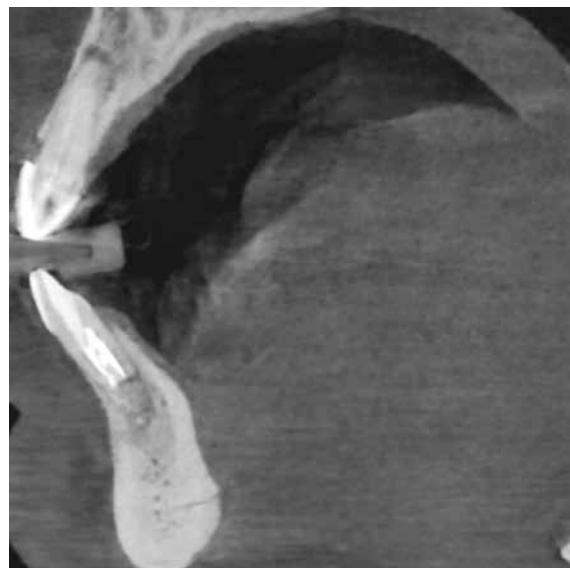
CBCT cross section at 6 months demonstrating replacement of the Bond Apatite® with new host bone maintaining the facial contour of the mandible that was affected by the lesion.
